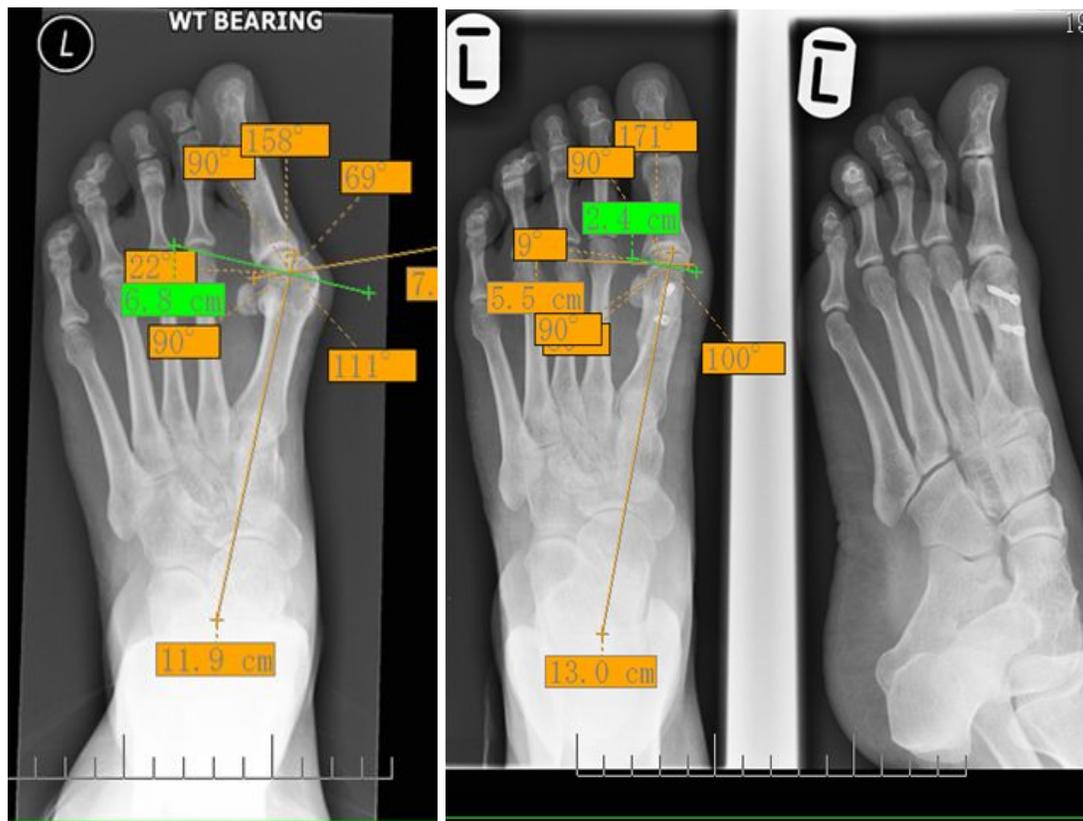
Pre-op and post-op radiographs displayed on computer system GE Centricity™, to highlight the DMA, IMA and, HVA respectively.
